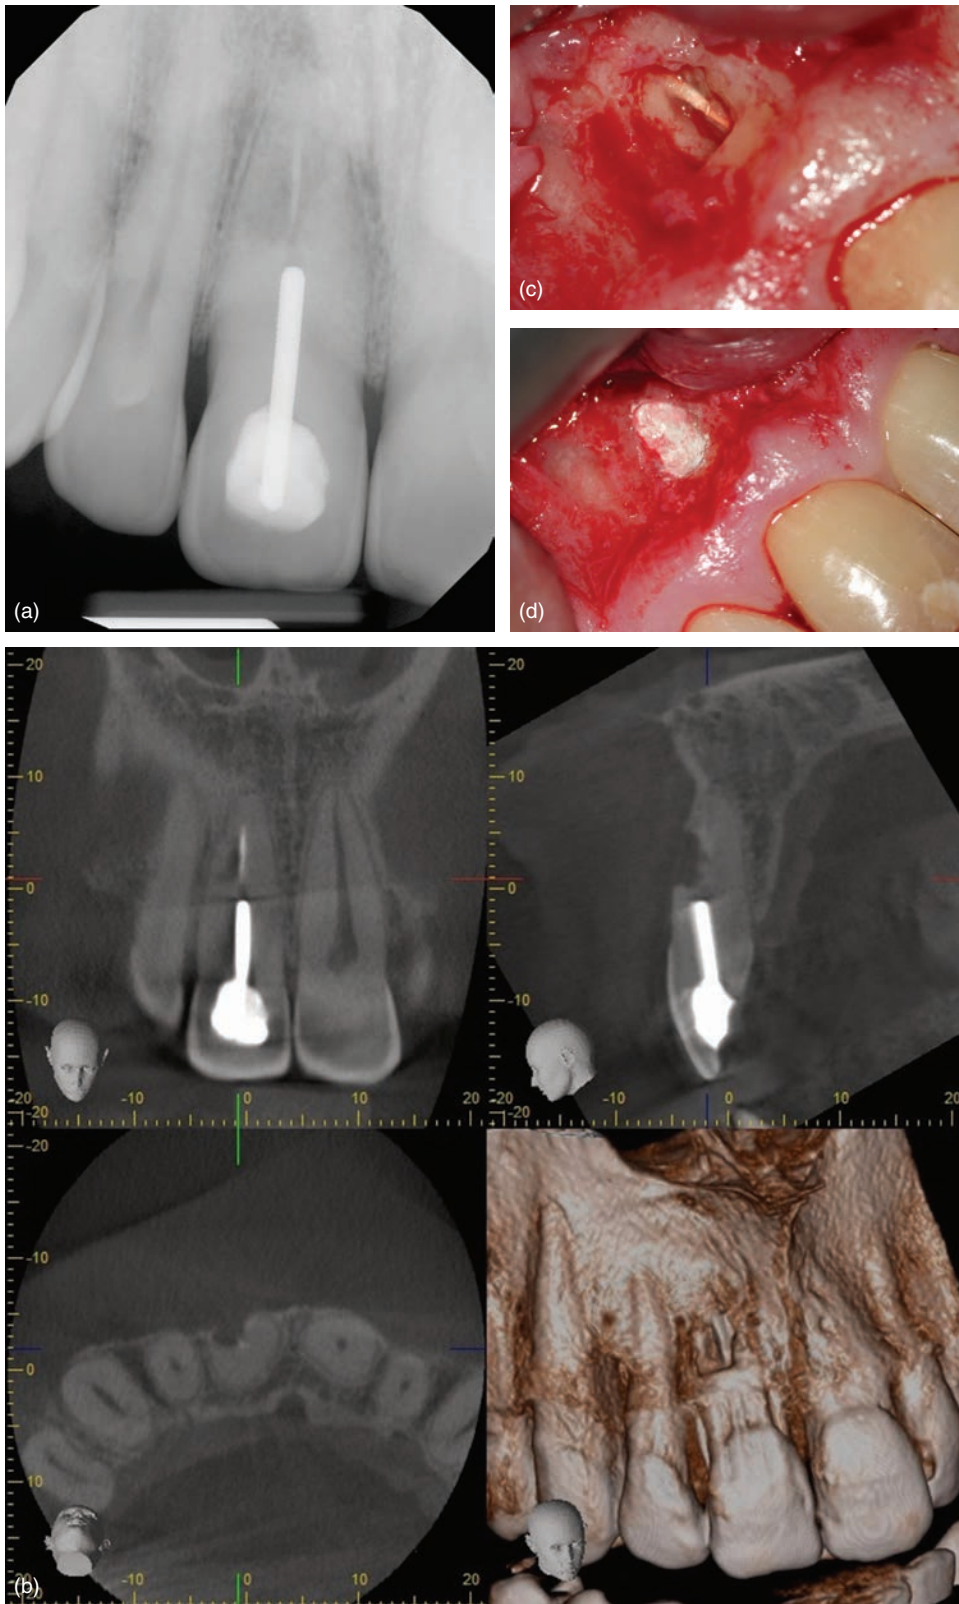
Previously treated maxillary central incisor with a large post and root resorption. (a) Preop radiograph. (b) CBCT images showing buccal mid-root root perforation with denuded buccal cortical bone. (c) and (d) Intraoral pictures showing the resorptive defect and the repair with Bioceramic root repair material. Due to the location of the bone defect and intact apical bone, apical resection was not performed.
